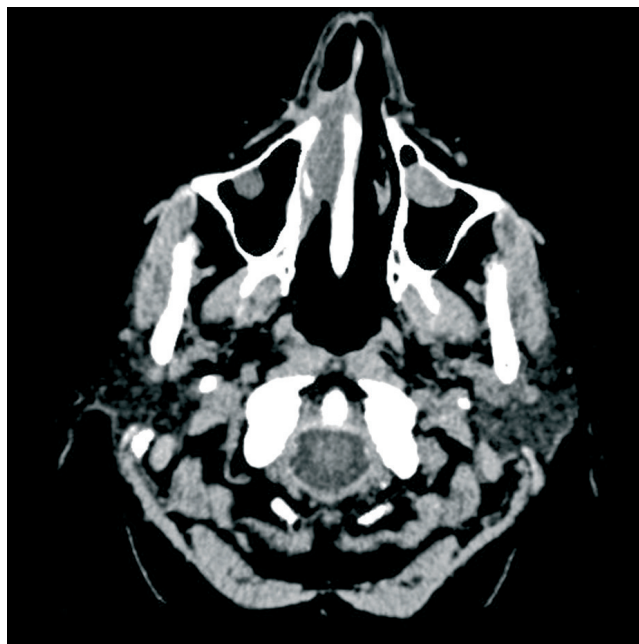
Computed tomography images showing local recurrence within the right nasal canal.
